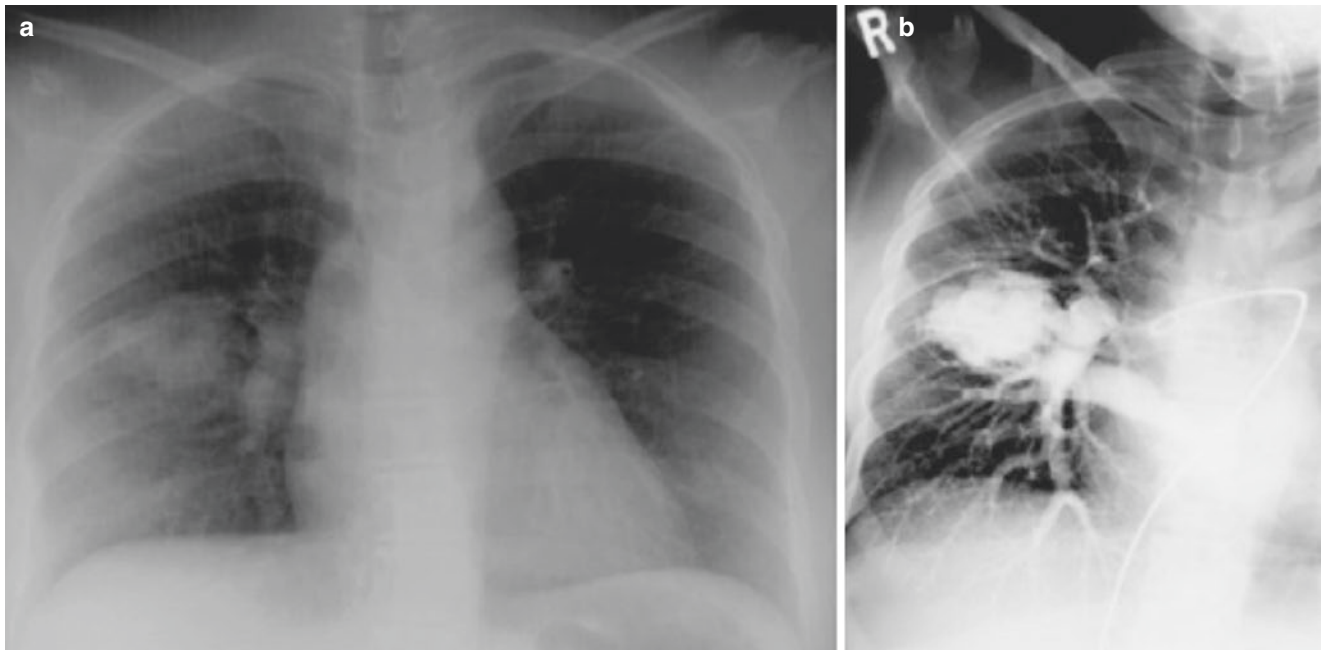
A 15-year-old girl with a pulmonary arteriovenous malformation who presented with hemoptysis. (a) Frontal chest radiograph shows a right parahilar nodular opacity. (b) Angiography demonstrates a mass-like tangle of vessels forming a pulmonary arteriovenous malformation
